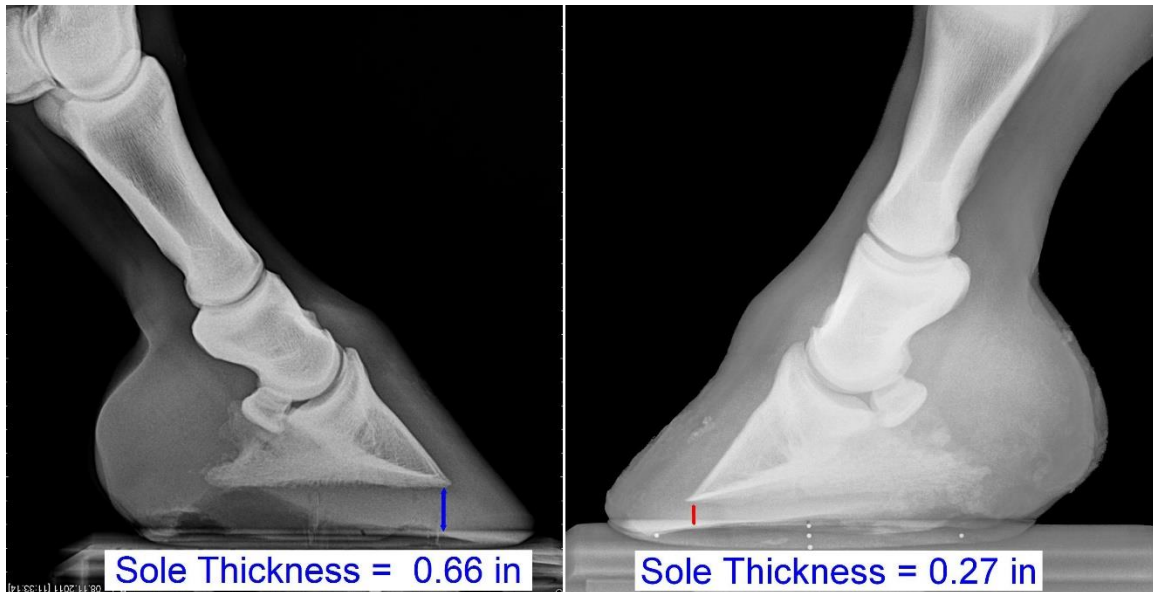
A lateral radiograph can help you assess the thickness of the sole. The radiograph on the left shows a hoof with good sole depth. The radiograph on the right shows a hoof with marginal sole depth.
